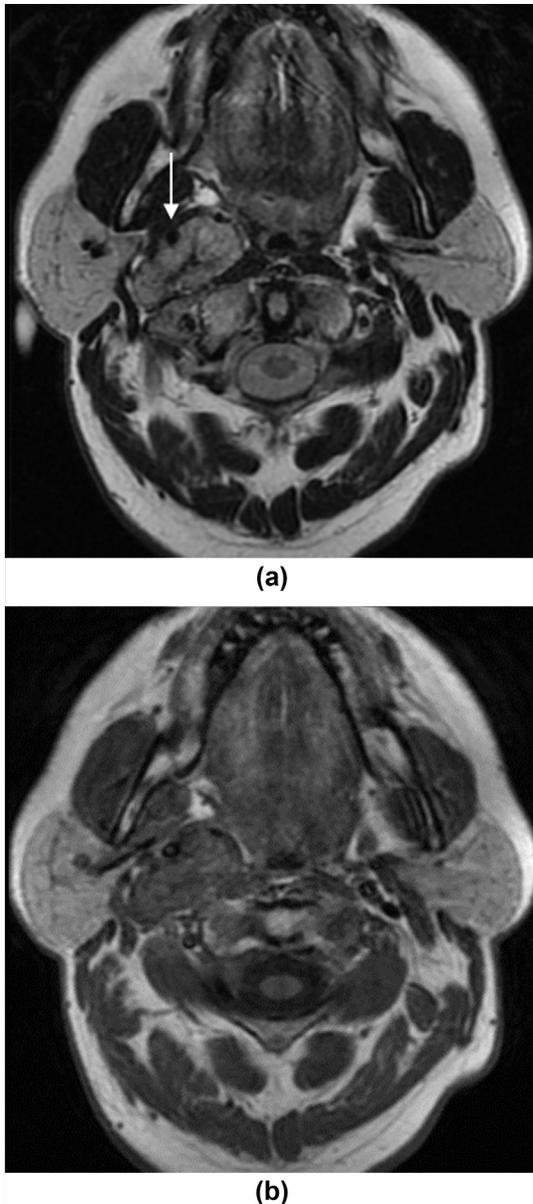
(a) Axial T2-weighted MRI appearance of a right-sided vagal paraganglioma. There is moderately elevated peripheral T2 signal with central low signal indicating fibrosis. Anterior displacement of the internal carotid artery (arrow) indicating the paraganglioma is likely arising from the vagus nerve. (b) Corresponding axial T1-weighted image showing intermediate signal within the paraganglioma.
